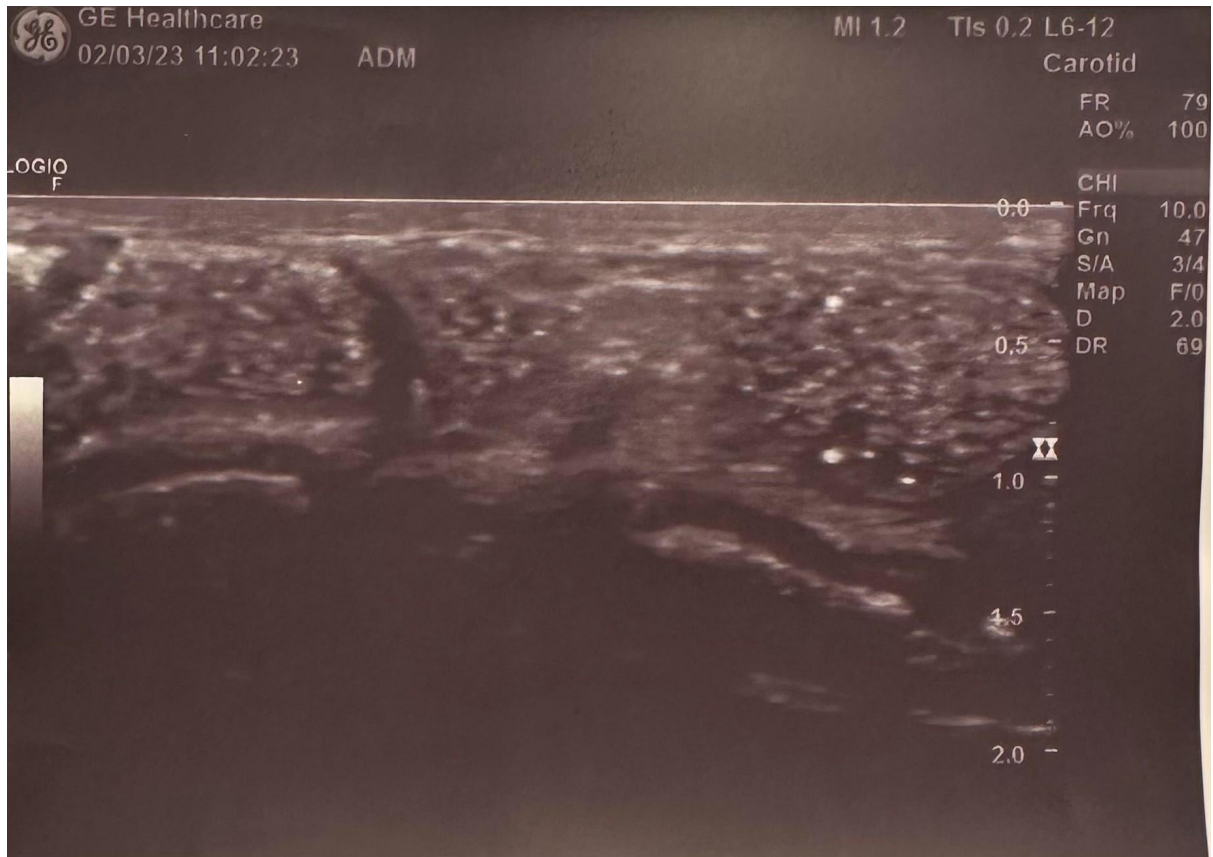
Longitudinal ultrasound scan of the inguinal canal with a hyperechoic intestinal loop containing gas bubbles.
